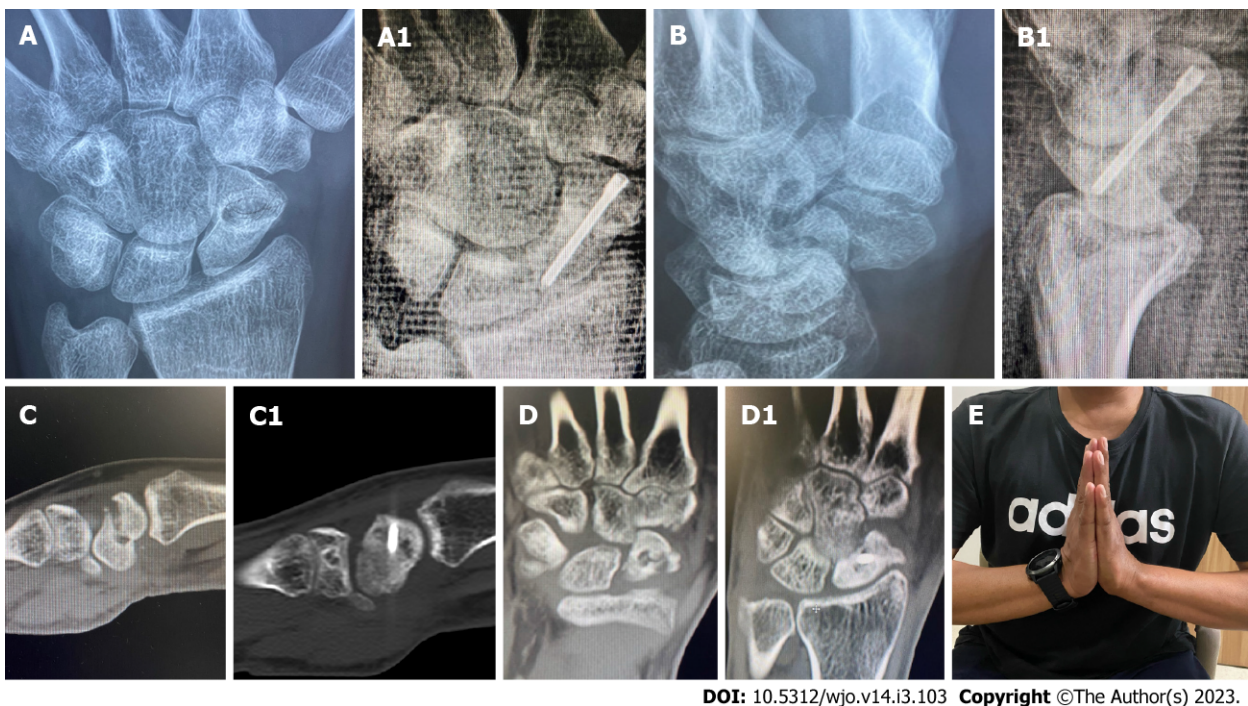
Arthroscopic fixation and bone grafting in scaphoid non-union. A and B: Pre-operative X-rays; C and D: Computed tomography scans of nonunion scaphoid, showing no bony bridge and humpback deformity. The nonunion and humpback deformity was successfully healed and corrected (A1, B1, C1 and D1); E: Post-operative clinical image after five months demonstrating good and painless range of motion.
